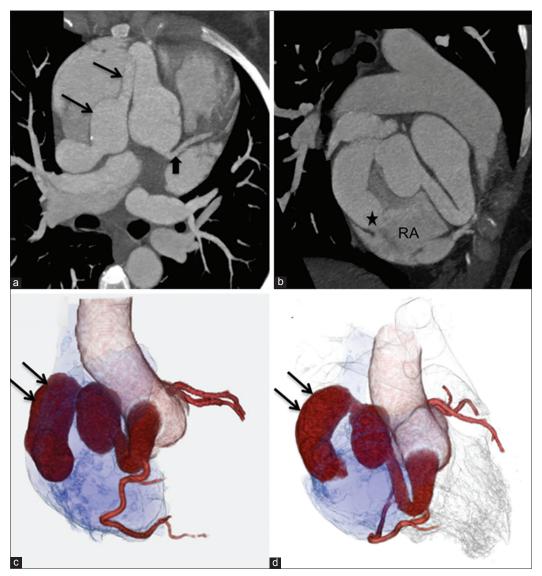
(a-d) Curved multiplanar reformatted contrast-enhanced computed tomography images (a and b) show a large and tortuous of right coronary artery (CA) fistula (arrows) draining into the right atrium in keeping with CA fistula. The left CA (block arrow in b) is arising normally from the left coronary cusp and is a normal caliber artery. Three-dimensional volume rendered (VR) computed tomography images (c and d) give an accurate depiction of the course of fistula and its relation to adjacent vascular structures
